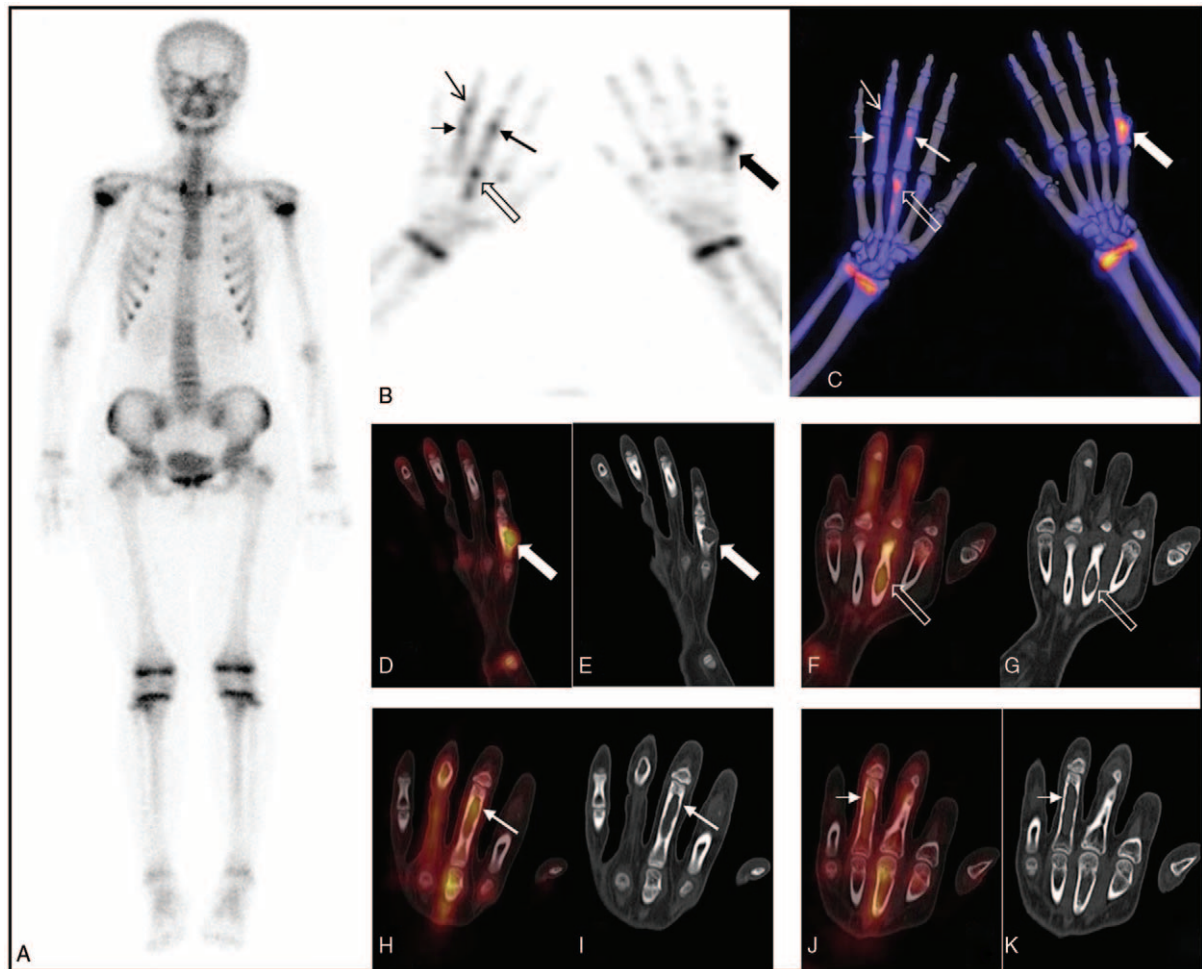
The ^{99m}Tc -MDP SPECT/CT image revealed dilated osteopathy and increased activity of the fifth proximal phalanx on the left side (the solid bold arrows on B, C, D, and E). In addition, unexpectedly, examination of the right hand revealed slight expanded lesions and high MDP uptake in the third metacarpal (the hollow thick arrows on B, C, F, and G) and proximal phalanges (the long arrows on B, C, H, and I), as well as the fourth proximal phalanges (the short arrows on B, C, J, and K) and the middle phalanx (the thin arrows on B and C). It was obvious that the above lesions can be observed more intuitively by 3D SPECT/CT fusion image (C).
